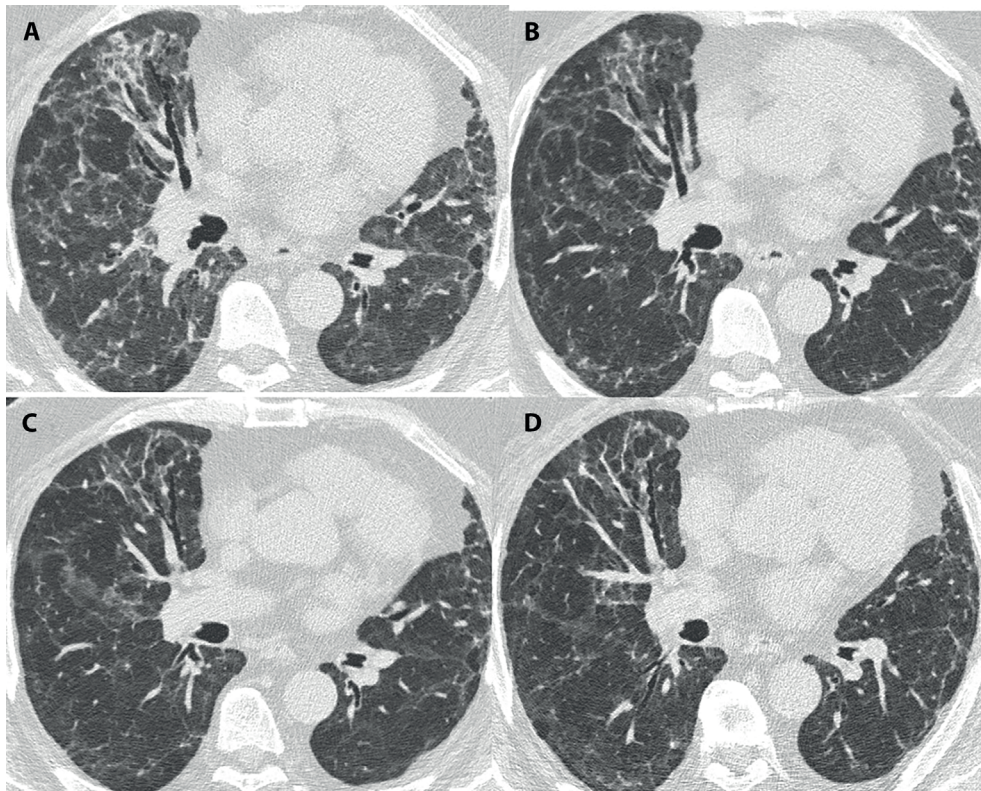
Follow-up high-resolution computed tomography images of a 67-year-old male patient who applied in the 2nd month of COVID-19 infection. Approximately similar HRCT sections passing through the basal level: A: before treatment, B: 1 month after immunosuppressive therapy, C: 3rd month, and D:6th month. There is a marked decrease in diffuse reticular areas accompanying the ground glass areas and a decrease in bronchiectasis density in areas with traction bronchiectasis.
